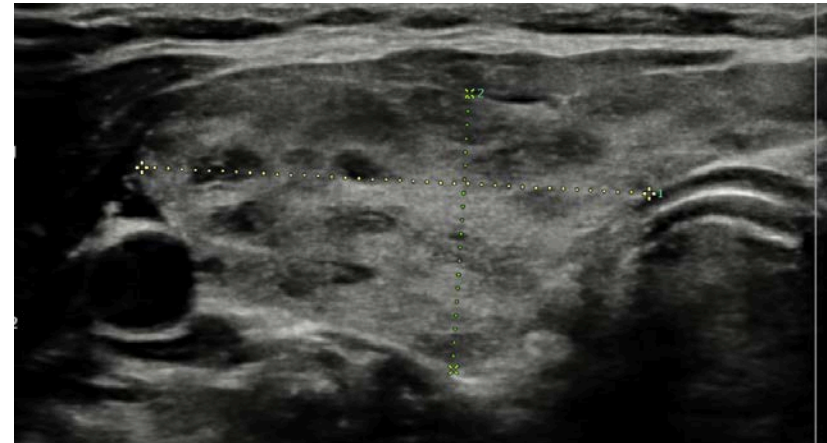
Transverse US and corresponding Doppler US image of the right thyroid lobe in a patient with an initial stage Hashimoto thyroiditis presenting with a characteristic «giraffe pattern»
